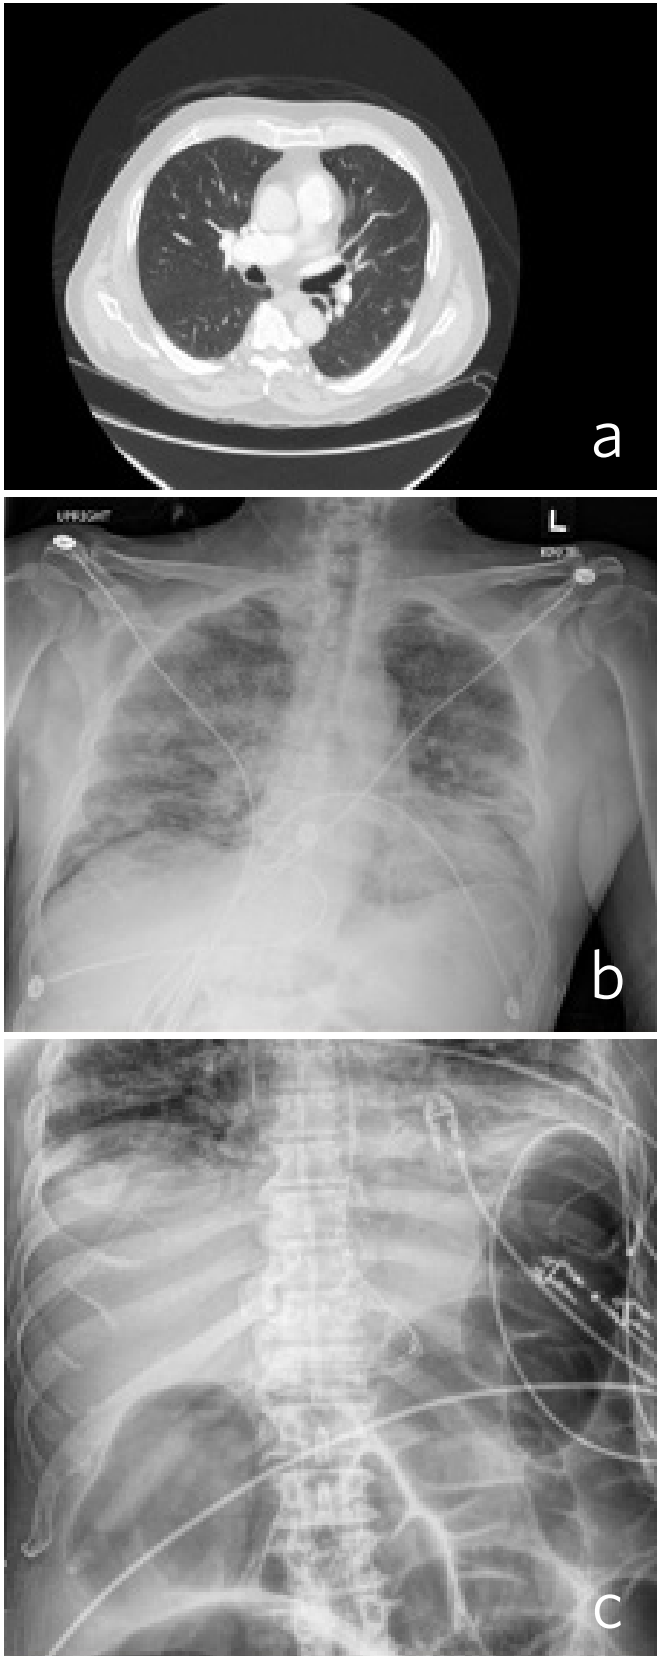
Case 1 CT imaging (a) CT angiogram of the chest showed signs of emphysema and chronic bronchitis; (b) CXR consistent with acute respiratory distress syndrome; (c) abdominal X-ray showing generalized large bowel dilatation
